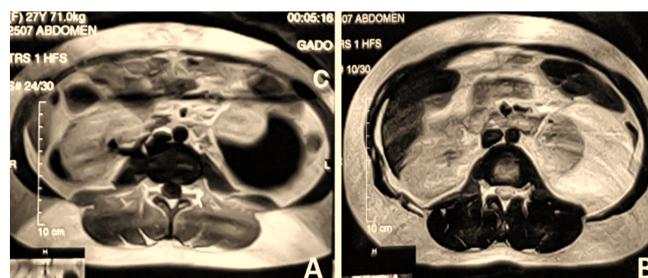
Abdominal magnetic resonance imaging. A: T1-weighted image (T1WI) shows bilateral asymmetrical perinephric fluid collections with homogeneous low signal intensity. B: T2-weighted image (T2WI) exhibits the same fluid collections with homogeneous high signal intensity.
